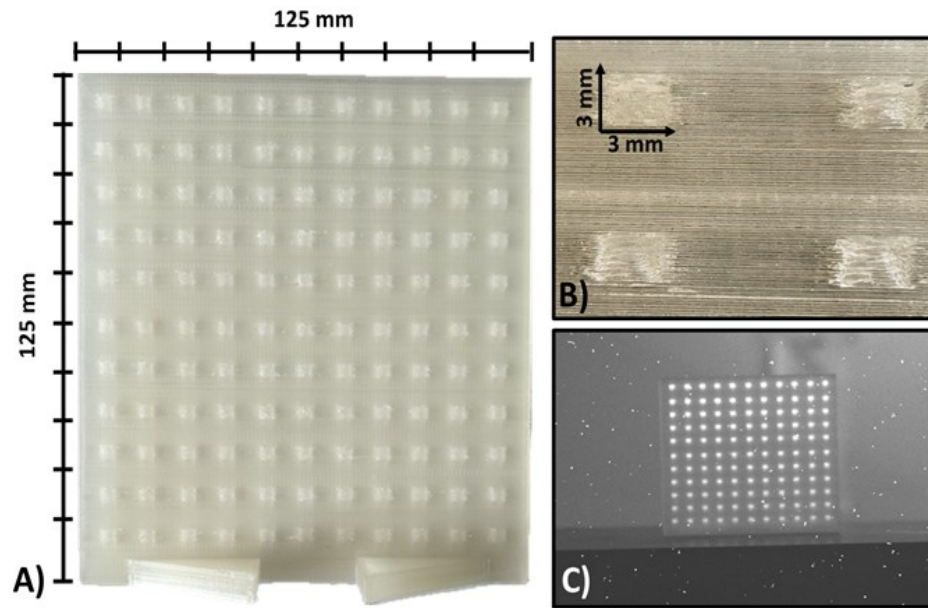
Images of dual-material 3D printed planar scintillator array, A) planar array, B) close-up of scintillating array elements and C) planar array irradiated by 6 MV X-rays.
